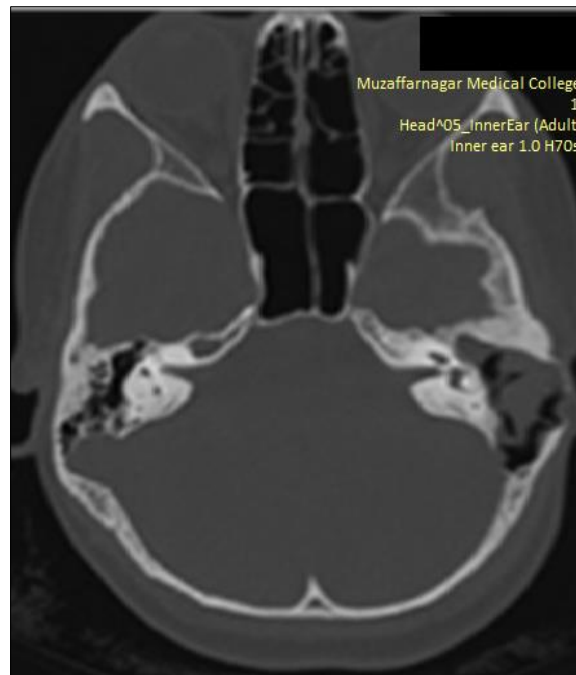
HRCT temporal bone axial section shows soft tissue density mass in the left middle ear cavity, aditus and antrum with the erosion of the sigmoid sinus plate and lateral cortical wall of the mastoid. Mastoid septae are eroded forming single cavity on left side.
